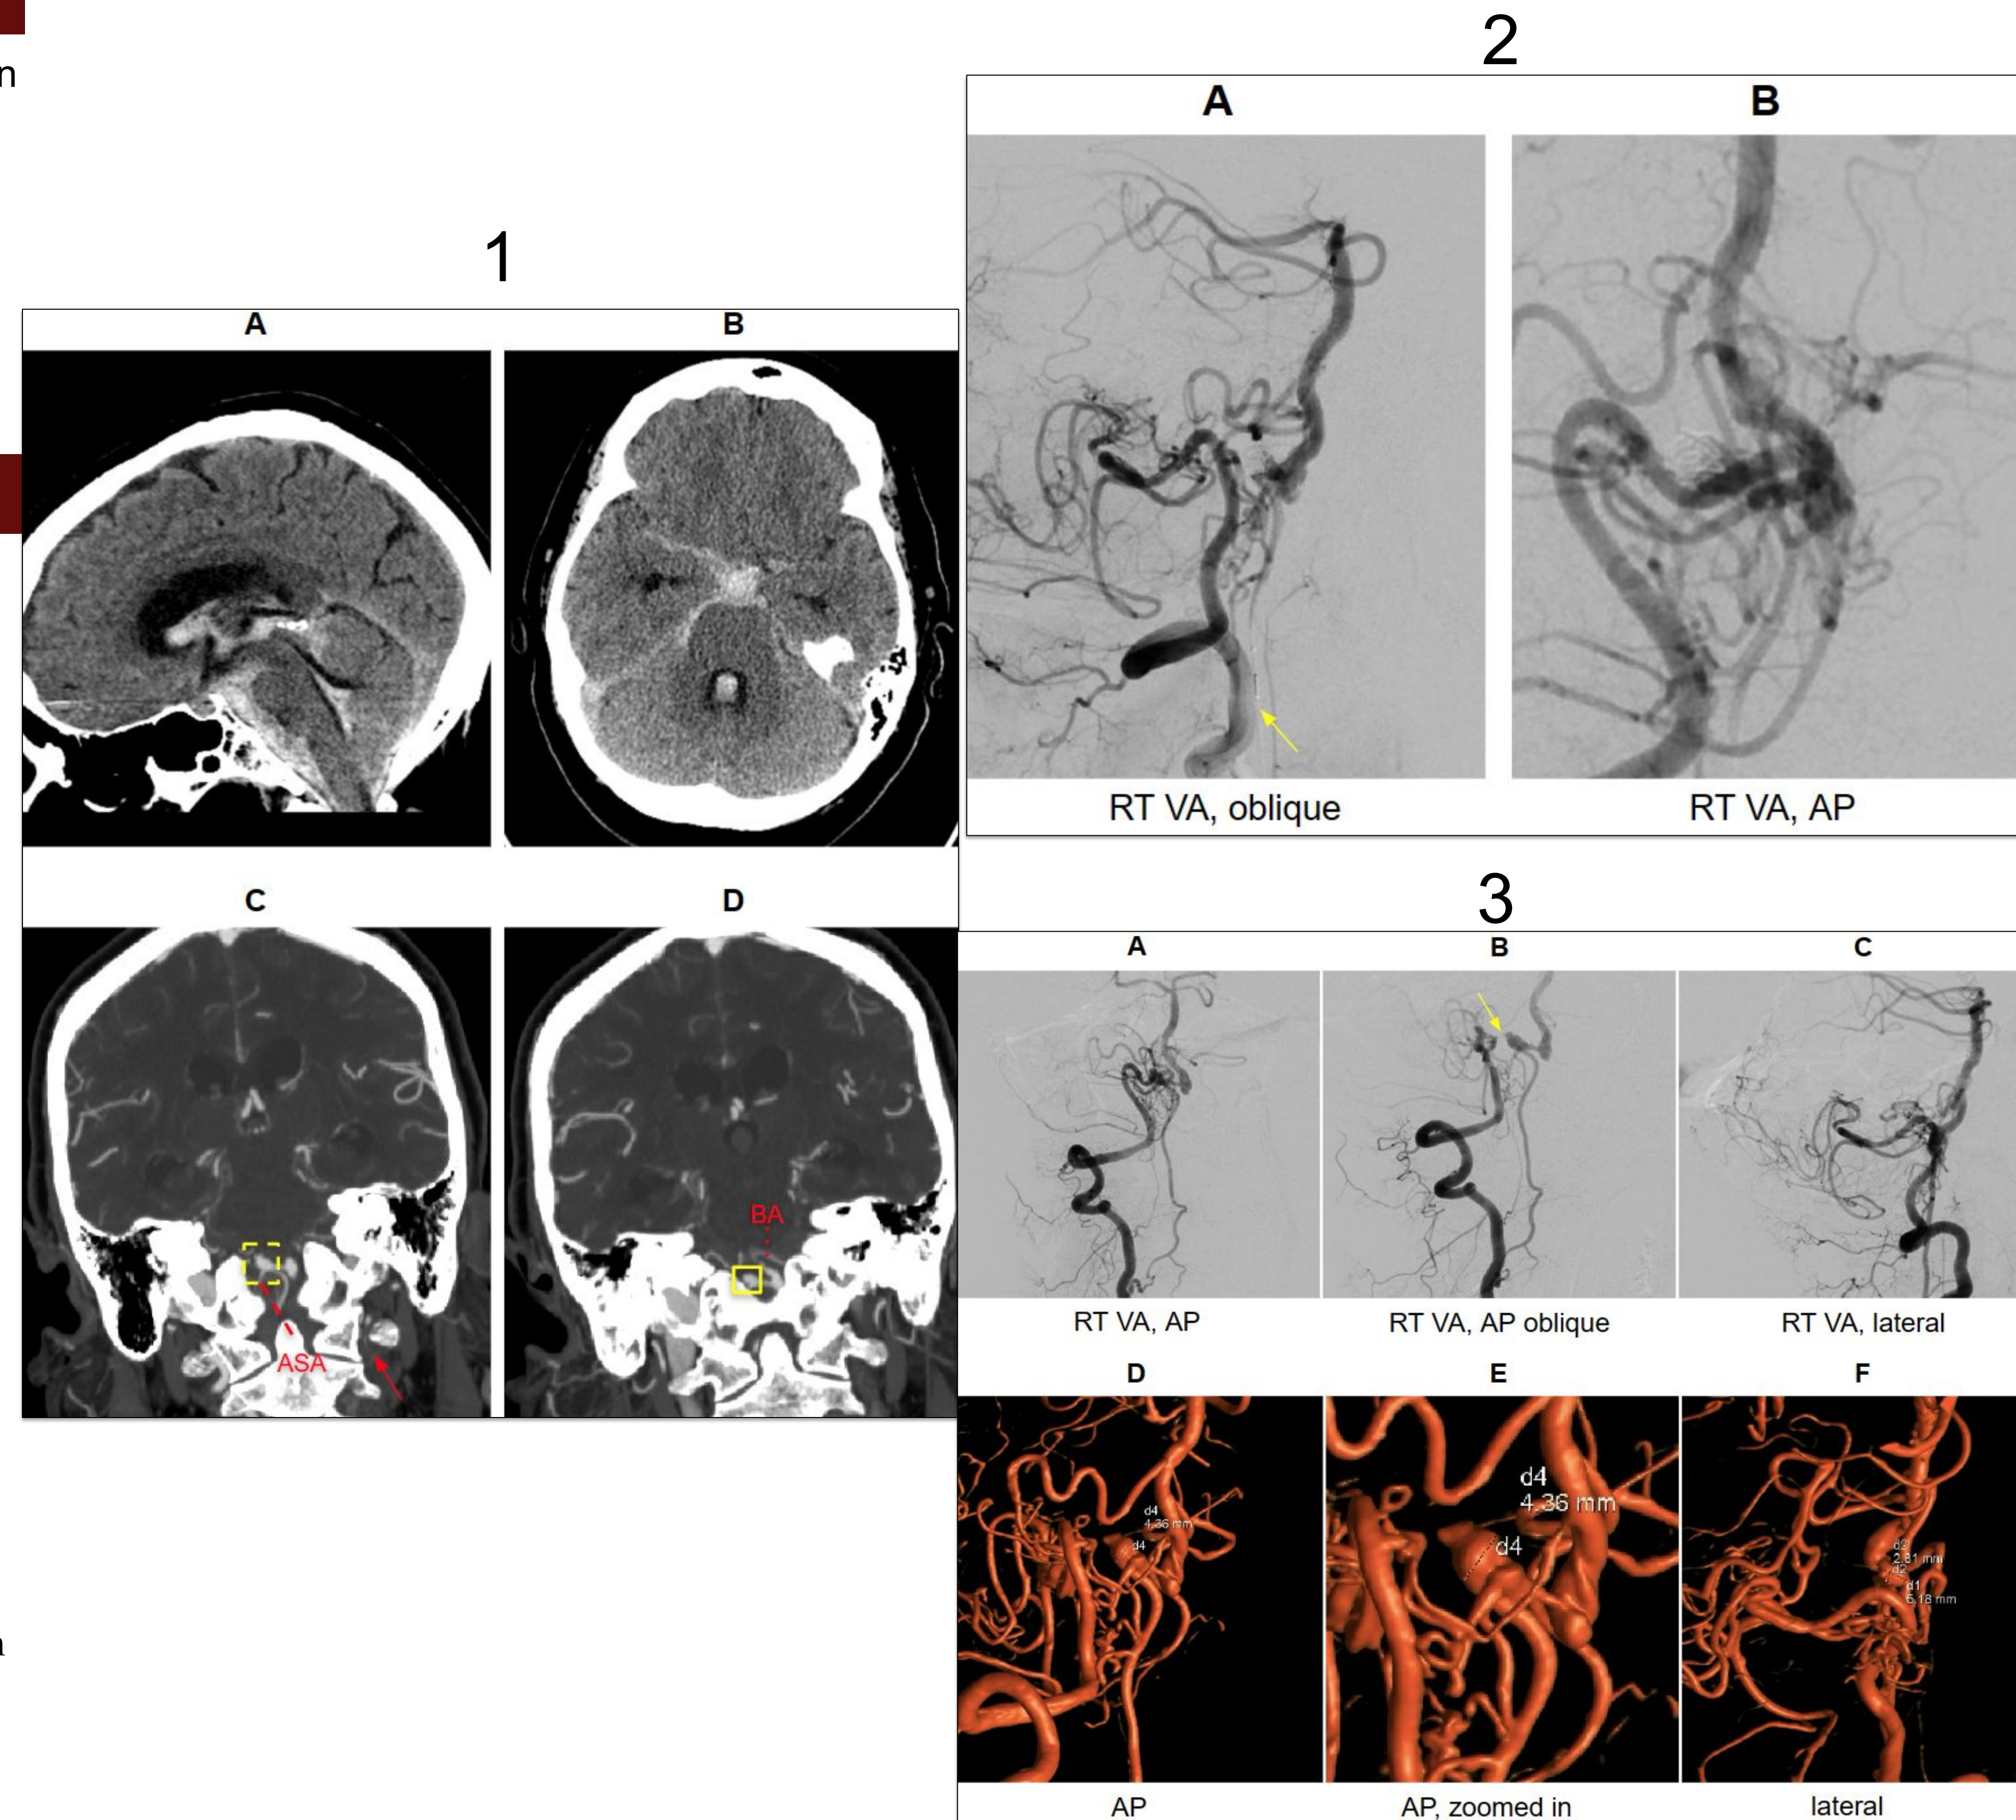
CT head and CT angiogram at presentation. (A-B) CT head without contrast (sagittal, axial) demonstrates diffuse subarachnoid hemorrhage in the basal cisterns with extension into the lateral, third, and fourth ventricles. (C-D) Coronal CT angiogram demonstrates unique vertebrobasilar anatomy with an absent left VA (red arrow, C) and an occluded right VA terminating in the PICA. A complex, bilobed aneurysm was seen at the ASA-VA junction (yellow box, C-D). Abbreviations: ASA, anterior spinal artery; PICA, posterior inferior cerebellar artery; VA, vertebral artery.
